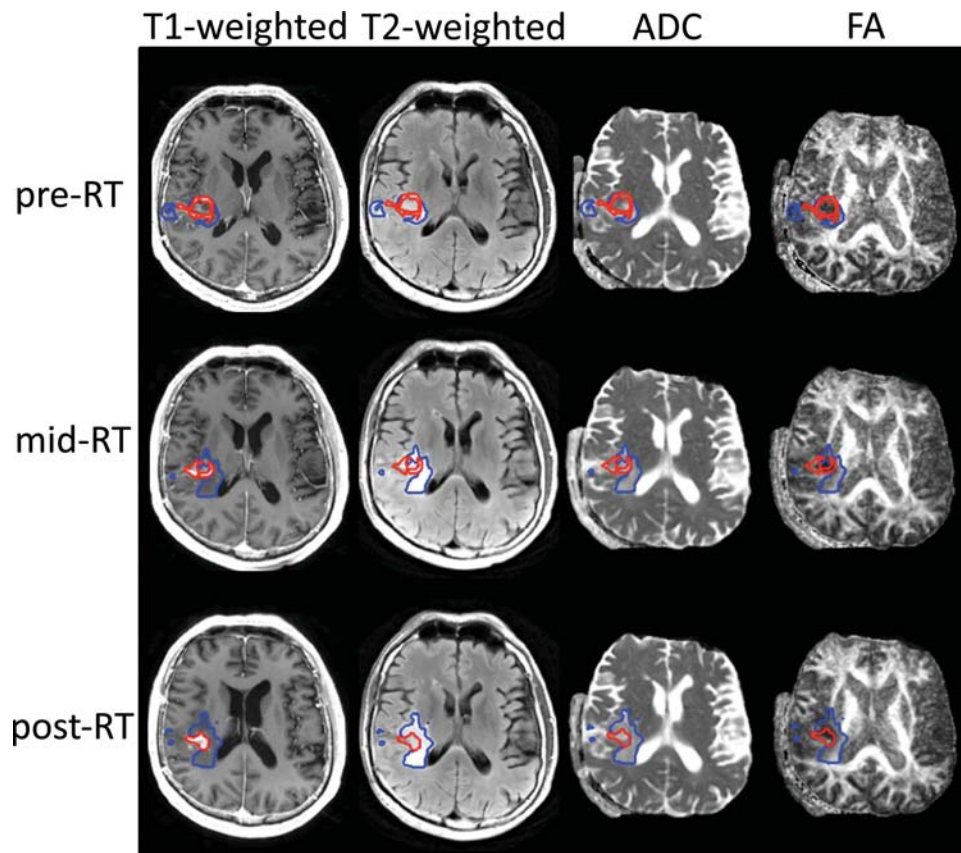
First, pre-RT T2- aligned to T1-weighted images. Next, T2 from diffusion imaging aligned to T2-weighted image and applied to diffusion maps (eg, ADC and FA). Aligning the individual pregadolinium T1-weighted images then aligns the mid- and post-RT scans to the pre-RT scans. Finally, apply the previous individual mid- and post-RT transformation to all the images at that time point (eg, FLAIR, ADC, and FA). The NEL (blue) and CEL (red) are shown for the individual scan time points.
